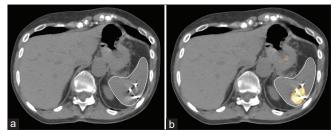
Computed tomography scan displaying successful placement of fiducial gold markers (a). Computed tomography/positron emission tomography scan highlighting both the tumor and fiducial gold markers (b)
